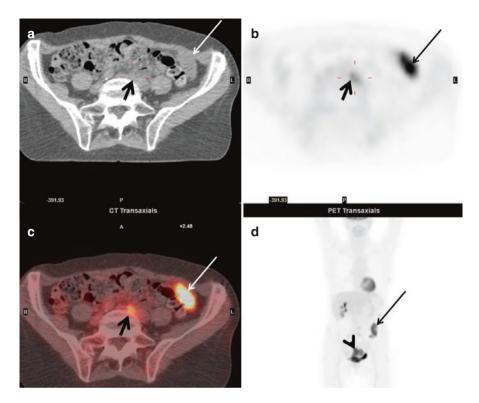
Detection of unsuspected metastatic disease with FDG PET-CT. 69-year-old female with rectosigmoid cancer. Conventional imaging revealed a rectosigmoid carcinoma with solitary left omental deposit. On FDG PET-CT the omental deposit (long arrows) and the rectosigmoid primary (arrow head on MIP image d) both demonstrated high intensity FDG uptake. However in addition a left para-aortic node also demonstrated high intensity uptake (thick short black arrows) highly suspicious for metastatic retroperitoneal nodal disease making the patient unsuitable for curative surgery
